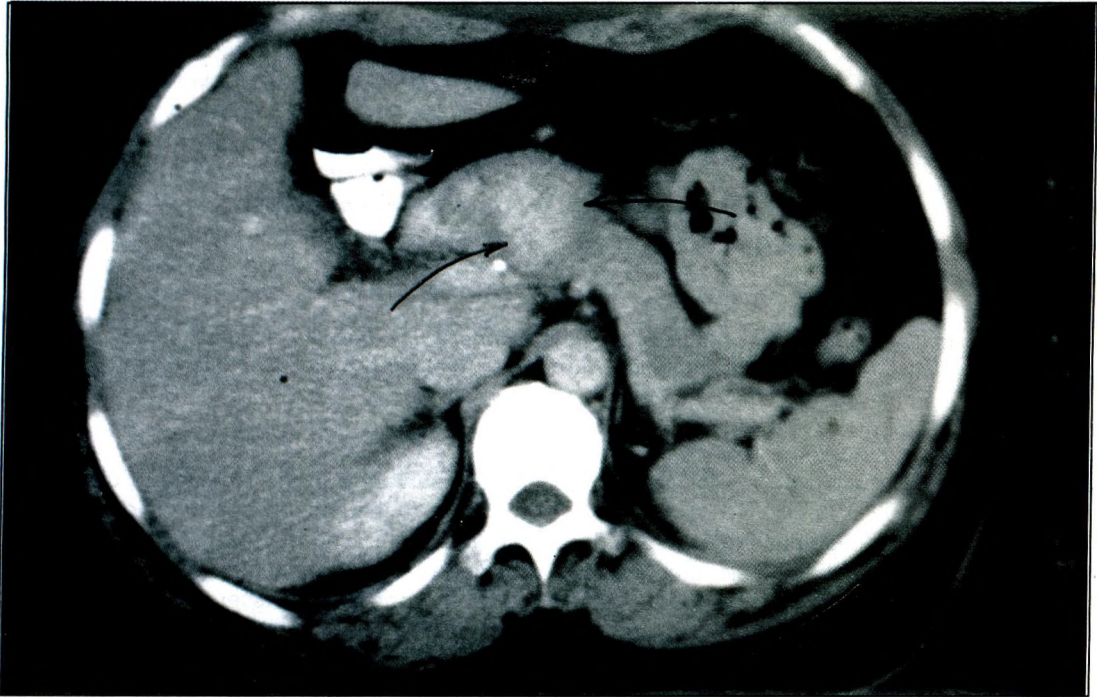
CT appearance of the gastric glomus tumor. Note the contrast enhanced homogeneous appearance of the mass. No perigastric involvement and lymph node.
